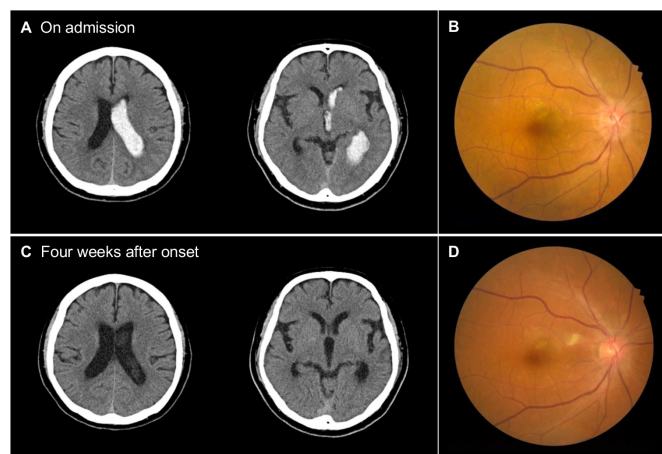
The CT imaging and ocular fundus findings of the right eye on admission (A, B) and 4 weeks after admission (C, D). (A) Intraventricular haematoma dominated in the left lateral ventricle on admission. (B) The papilloedema of the right fundus, which was also present on the left eye (photograph not shown). (C) A mostly absorbed intraventricular haematoma in the fourth week after admission. (D) The papilloedema was improved, which was also observed on the left eye (photograph not shown).
